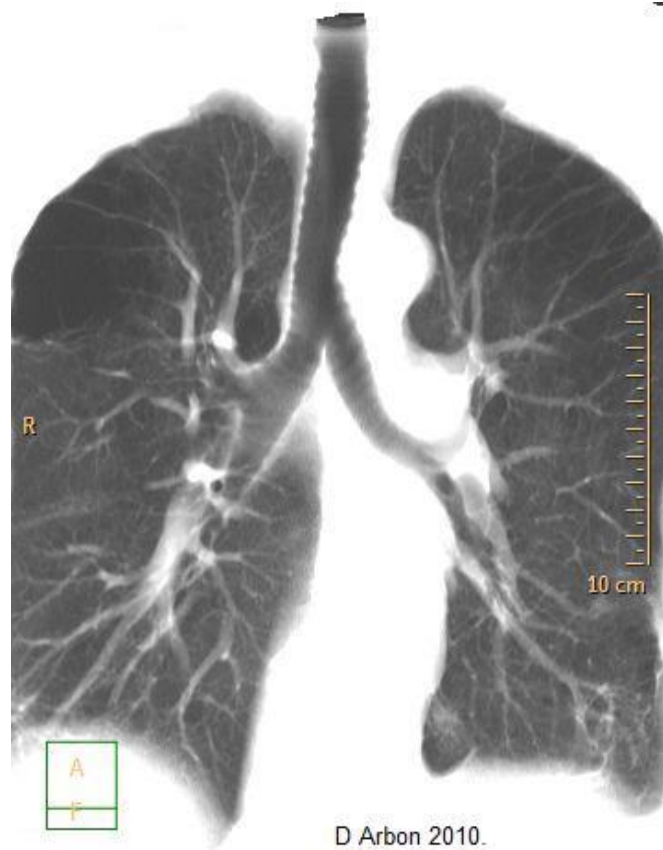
CT Scan of the human airways (Photo by Author)
